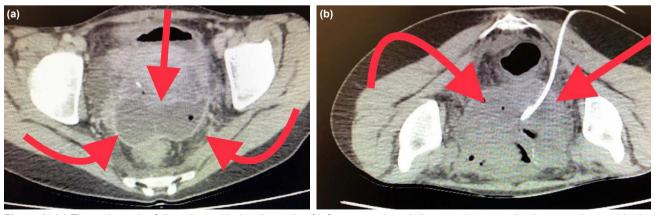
(a) The patient who followed up with the diagnosis of inflammatory bowel disease, abscess collection was observed in the uterus posterior. (b) Transgluteal drainage catheter was performed in the prone position under CT guidance. The abscess puncture was performed laterally of the piriformis muscle.
